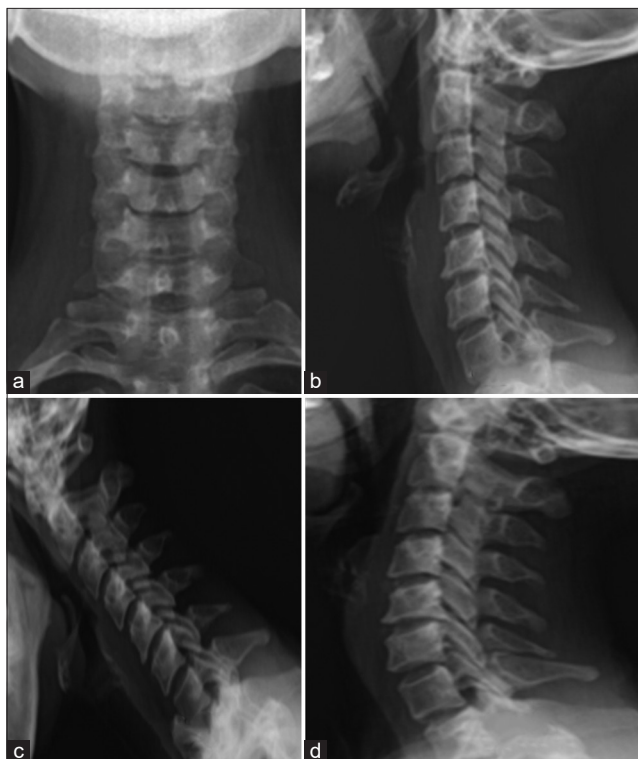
Preoperative X-ray – anterior-posterior view (a), lateral view – neutral (b), lateral view – flexion (c), lateral view – extension (d)
